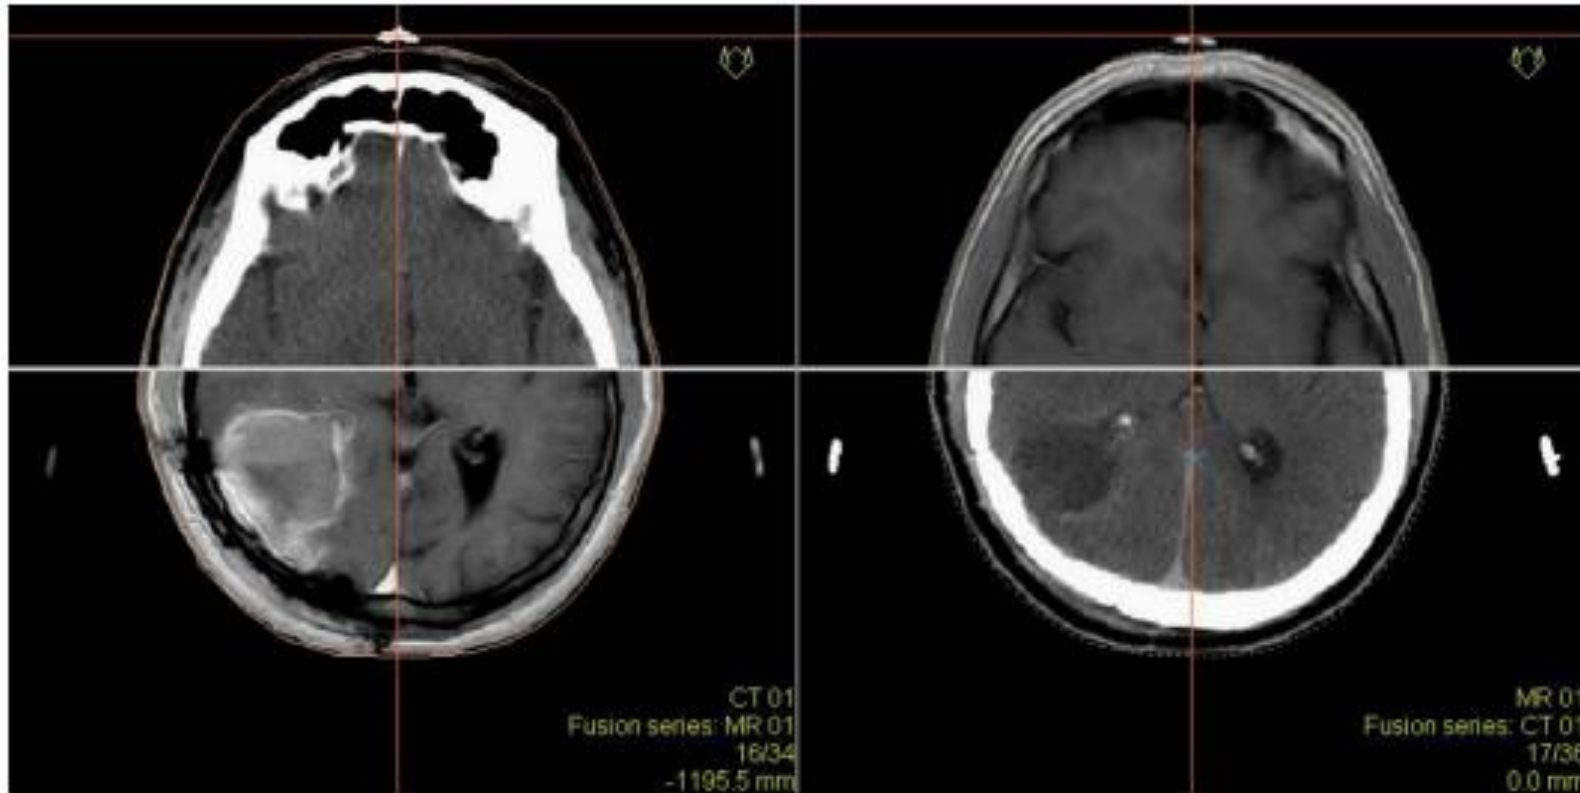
Image registration of CT and MR image sets. Left image: top (CT), bottom (MR). Right image: top (MR), bottom (CT). The center of the middle fiducial marker pointed out on the left image is shown via registration on the right.
